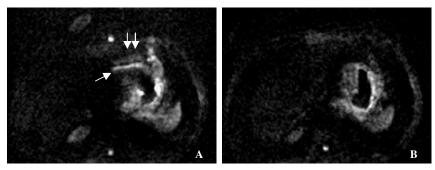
Gastric body cancer. A, DWI without parallel imaging, the signal of cancer was obviously distorted, severe susceptibility artifact can be seen at the gas-liquid level (white arrow), and ghost artifact was demonstrated (double white arrow); B, DWI with parallel imaging, the distortion and artifacts remarkably reduced or disappeared.
